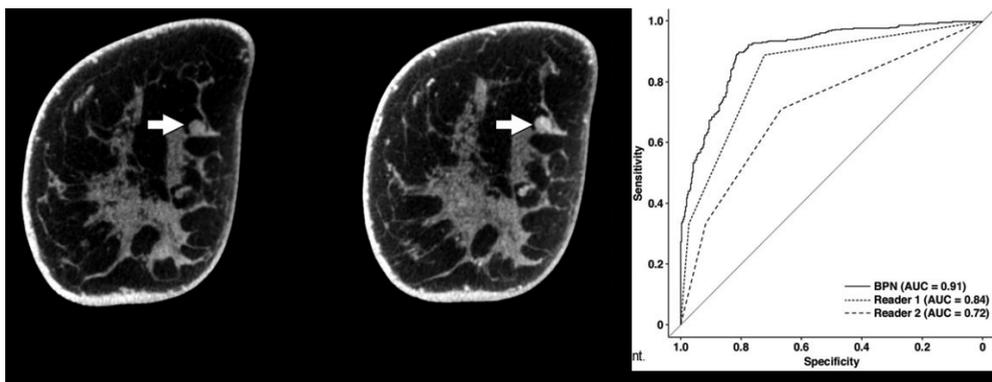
Deep Machine Learning: overall tendency to outperform readers in correct discrimination of benign vs. malignant lesions in breast CT (UHLIG et al. 2018).
